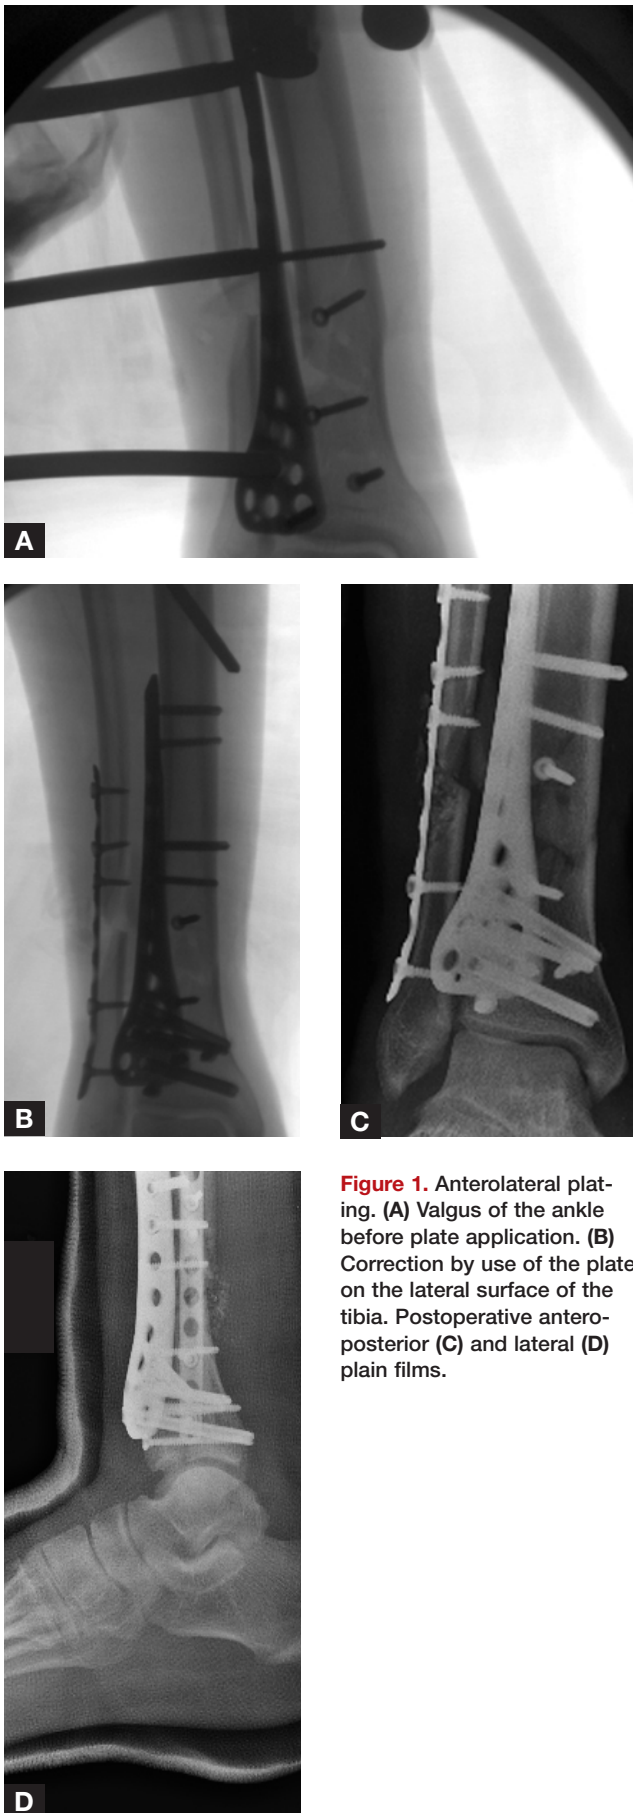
Anterolateral plating. (A) Valgus of the ankle before plate application. (B) Correction by use of the plate on the lateral surface of the tibia. Postoperative anteroposterior (C) and lateral (D) plain films.
